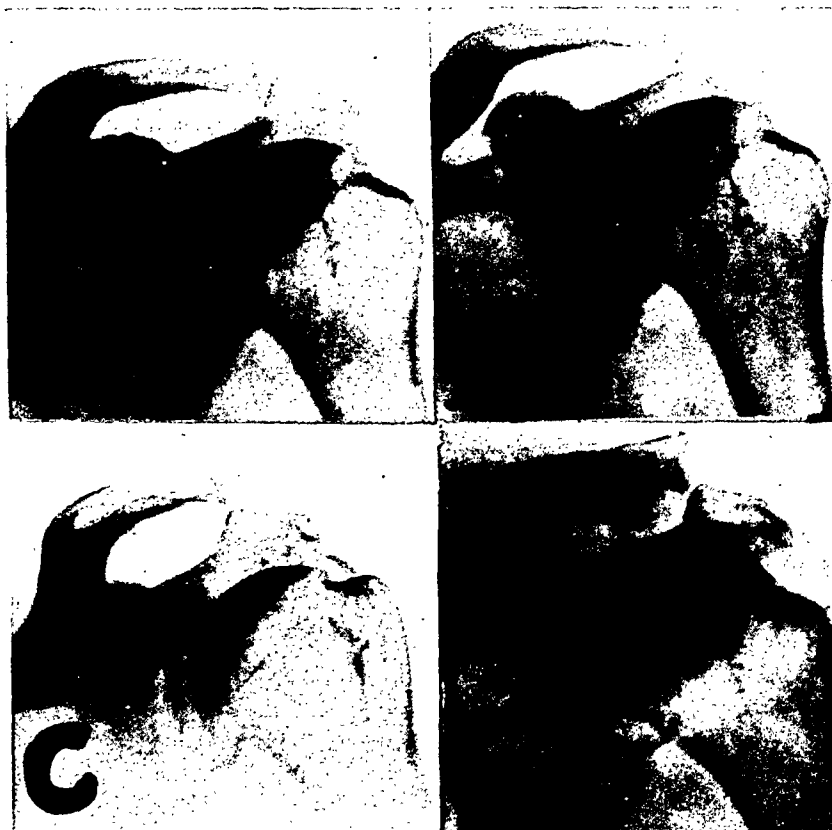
View of the left shoulder of a male (K. G., age 64). A and B were taken the same day after he was struck by an auto on the left shoulder. They show the position of the clavicle slightly above the level of the acromion but still within upper normal limits. C was taken in the same standing position, but patient held a 35 pound weight in each hand during x-ray exposure. It shows the clavicle entirely above the level of the acromion, justifying a diagnosis of torn coracoclavicular ligaments with acromioclavicular dislocation. D, taken nine weeks later. Shows the calcification in the region of the coracoclavicular ligaments, substantiating the former diagnosis of injury to the coracoclavicular ligaments with acromioclavicular dislocation.
